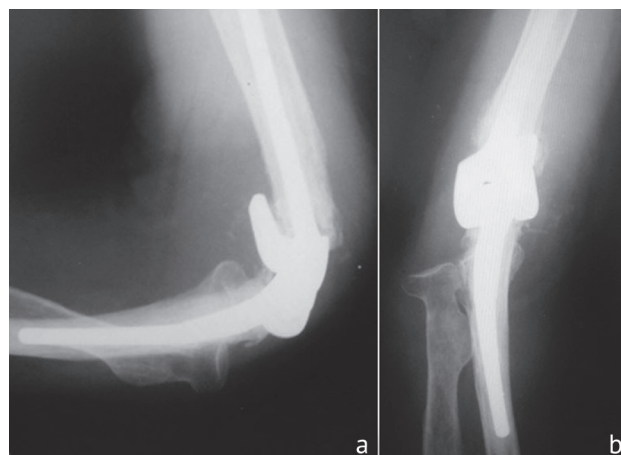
Patient C radiographs of the elbow joint 12 months after TEA: a – AP view, b – lateral view
